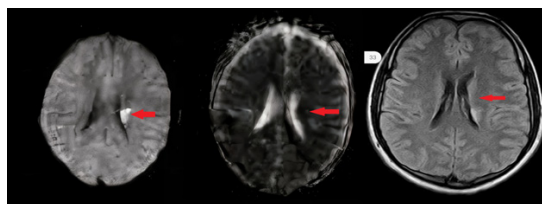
Brain MRI: An abnormal focal signal at the left parietal periventricular white matter. A bright T2/FLAIR signal with corresponding diffusion restriction in DW/ADC map imaging denoting its acute ischemic nature.
